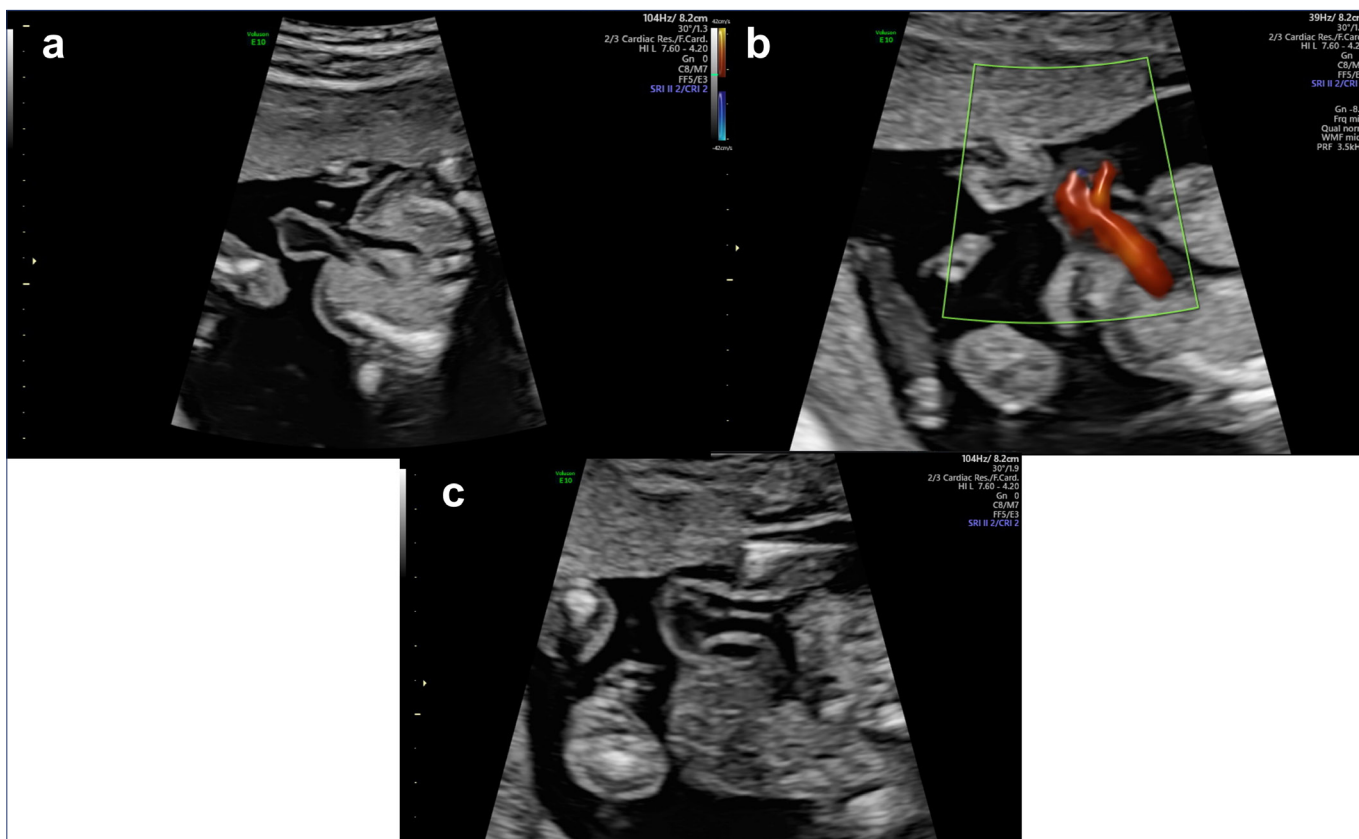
The heart appears to be outside the thorax at the thoracic level in transverse section. (a) Without Color Doppler; (b) With Color Doppler; (c) Left ventricular outflow.
